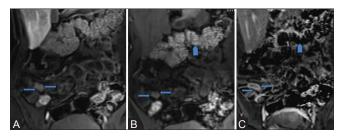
(A-C): (A) Coronal postcontrast T1-weighted image showing T1 hyperintense signal within the terminal ileum, suggesting enhancement related to active disease (arrow). (B) Corresponding Coronal precontrast T1-weighted image also showing T1 hyperintense signal within the terminal ileum, thus making it difficult to determine if the enhancement is true enhancement or not (arrow). Note the T1 hyperintense signal within the colon (arrow head) (C) Corresponding coronal postcontrast T1-weighted image with subtraction, confirming that the enhancement is a true enhancement and not artifactual from preexisting T1 hyperintense signal in the bowel wall (arrow). Note the suppression of T1 hyperintense signal in the colon with subtraction imaging (arrow head)
